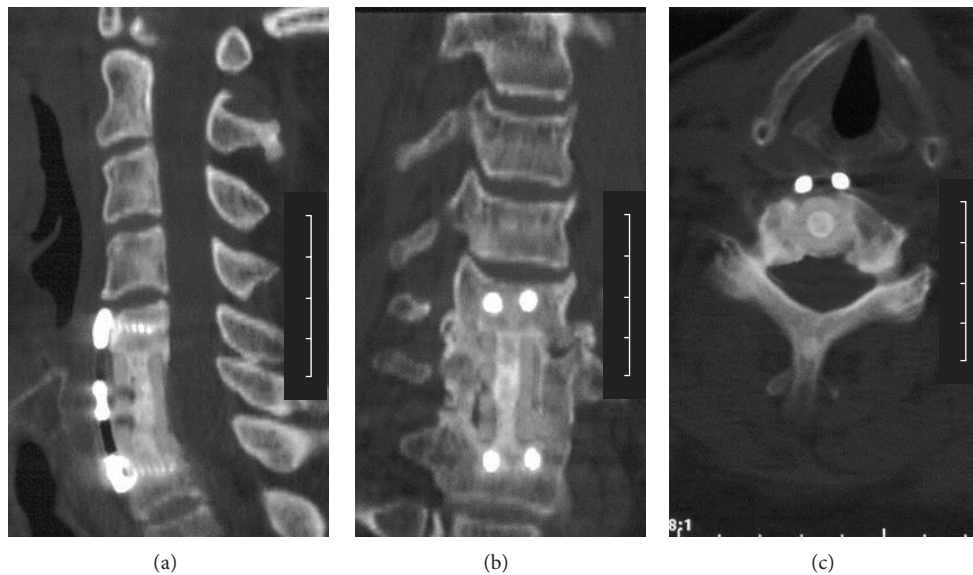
The same patient of Figure 5. One year after surgery solid fusion was seen on multiplane CT scan.
